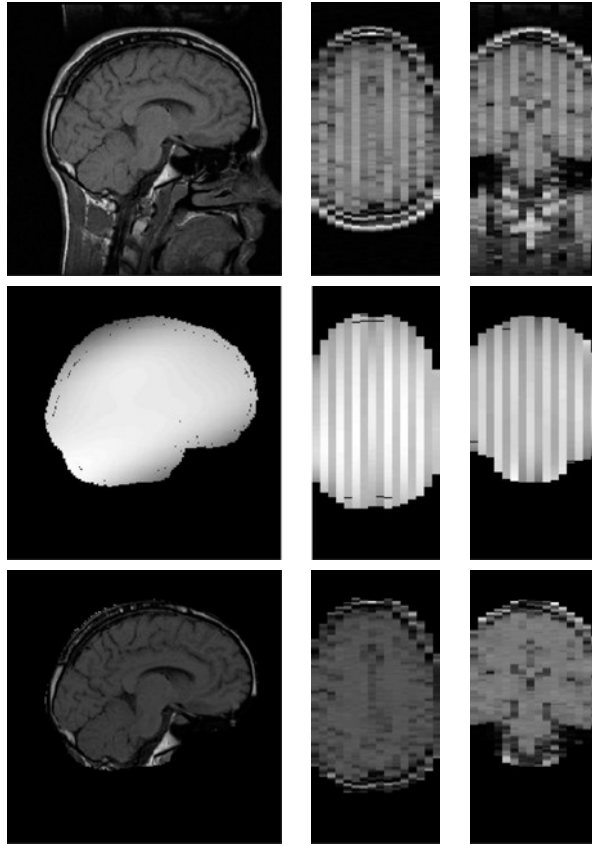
An example of bias correction of a T1-weighted 2-D multislice image corrupted with slice-by-slice offsets. From top row to bottom row: original data, estimated bias, corrected data. (Source: Ref. [23].)
